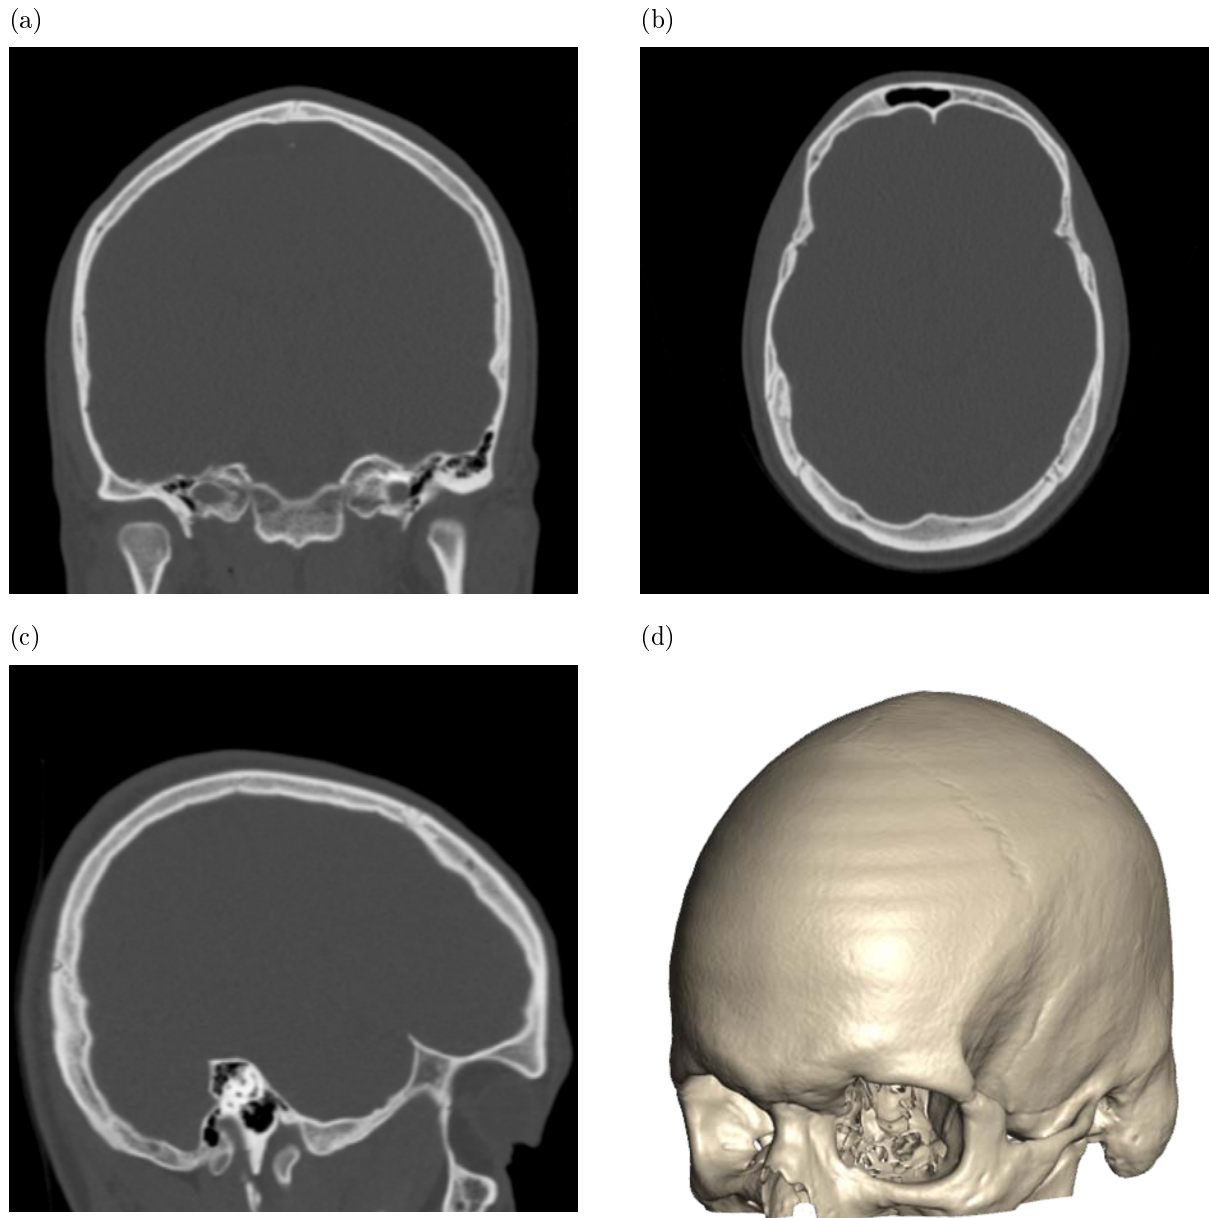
CT cranium images and 3D reconstruction. (a) Coronal view of a CT cranium image. (b) Horizontal view of a CT cranium image. (c) Sagittal view of a CT cranium image. (d) 3D reconstruction of CT cranium image (see Figure 5.1 for description of how to construct 3D from 2D images through segmentation).
